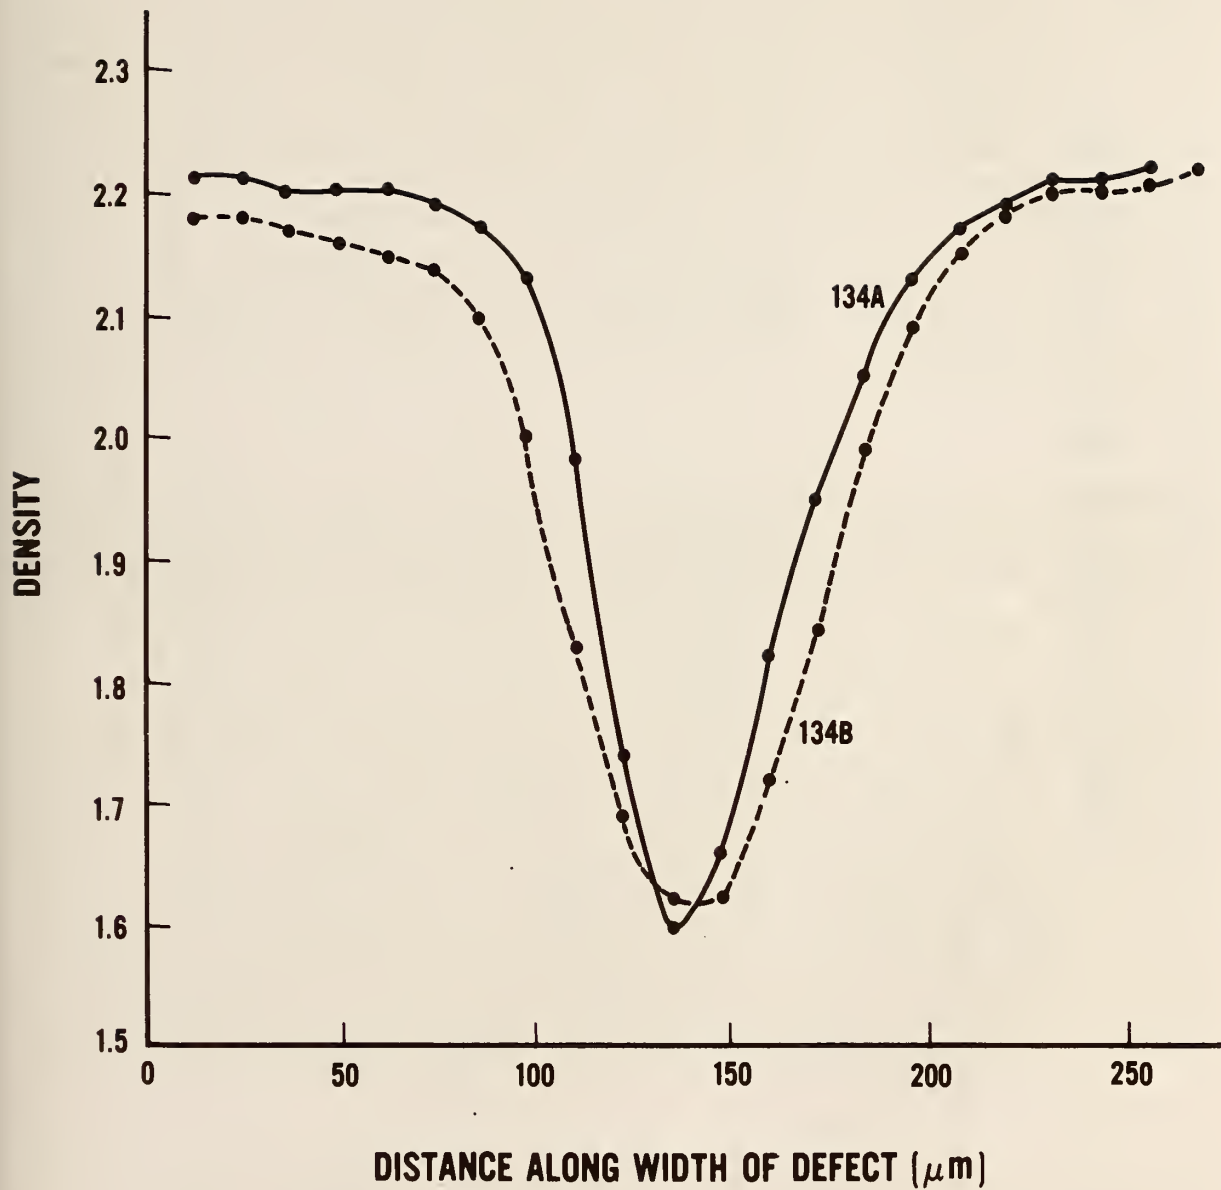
Density distribution of cracks from real world radiographs of aircraft wing samples. Defect lighter than background.
